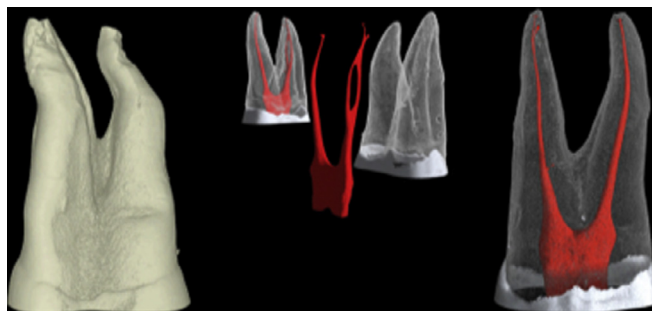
Colour coded images of extracted premolars using Micro CT Imaging data showing the pulp chamber and the pulp canal.
